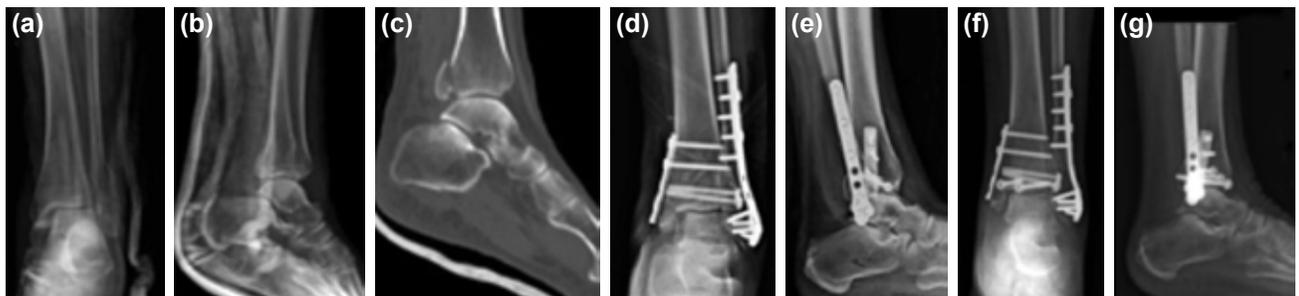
Posterior malleolus fracture treated with anteroposterior screw fixation (a) preoperative anteroposterior X-ray, (b) preoperative lateral X-ray, (c) preoperative sagittal section, (d) intraoperative anteroposterior X-ray, (e) intraoperative lateral X-ray, (f) postoperative 2-year X-ray, (g) postoperative 2-year lateral X-ray.
